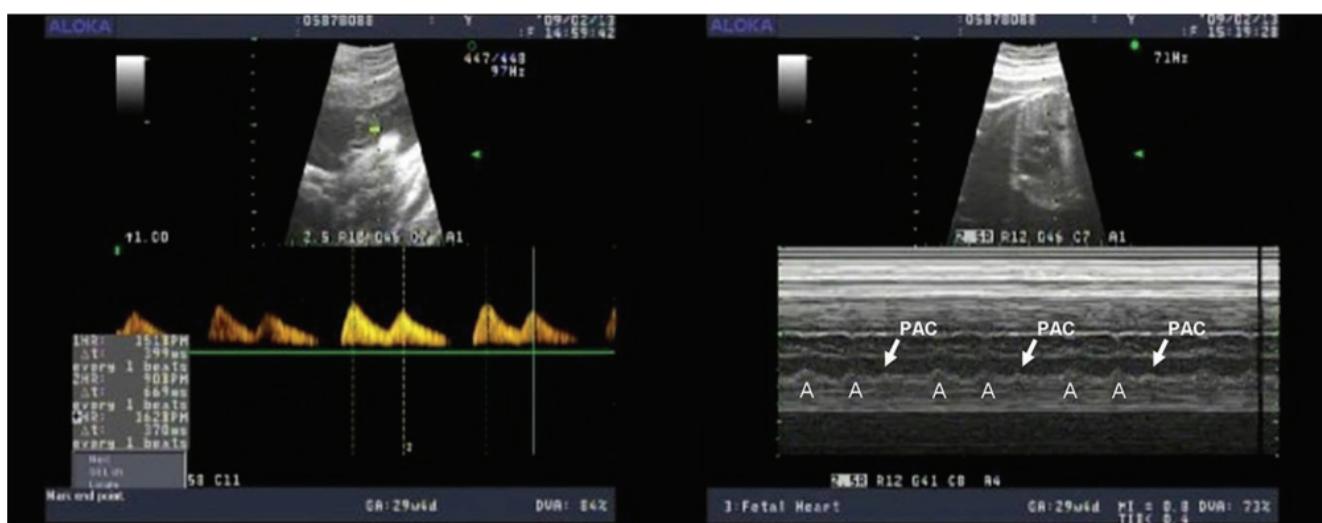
Pulse Doppler shows skipped beats and M-mode reveals blocked premature atrial contractions (PAC).
